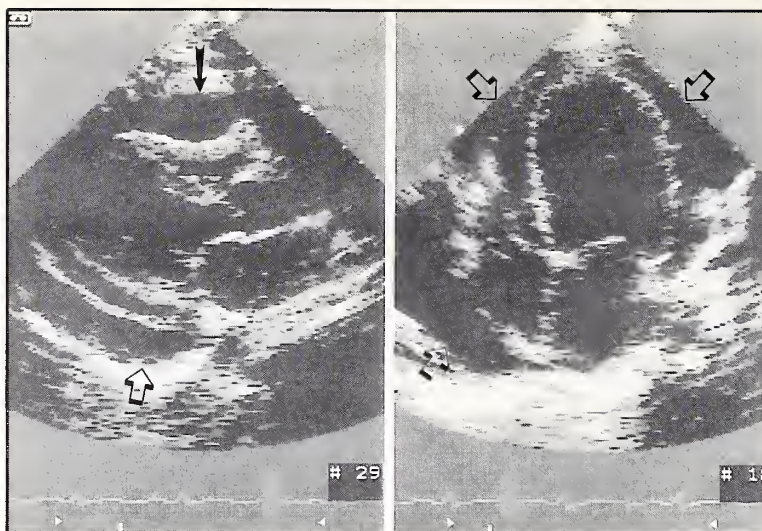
A large pericardial effusion is seen in the parasternal long axis (left) and apical 4-chamber (right) echocardiographic views in a patient with profound hypothyroidism. Arrows outline the pericardial effusion. (Figure courtesy of Nancy Patterson, RN, RCMS).
